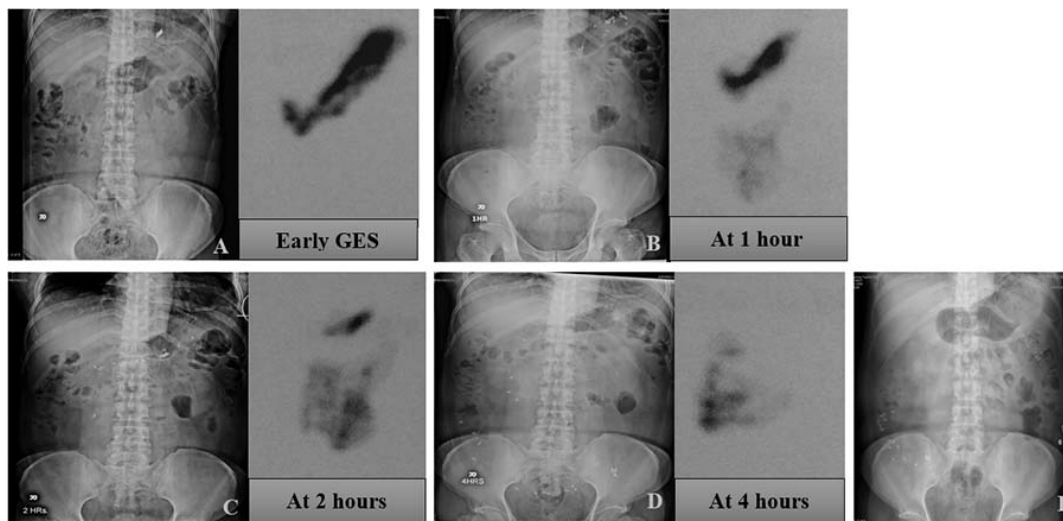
Imagings of a study participant demonstrated the retaining of gastric content by the radiopaque marker technique and the gastric scintigraphy technique. These were taken simultaneously at different time points as displayed.
